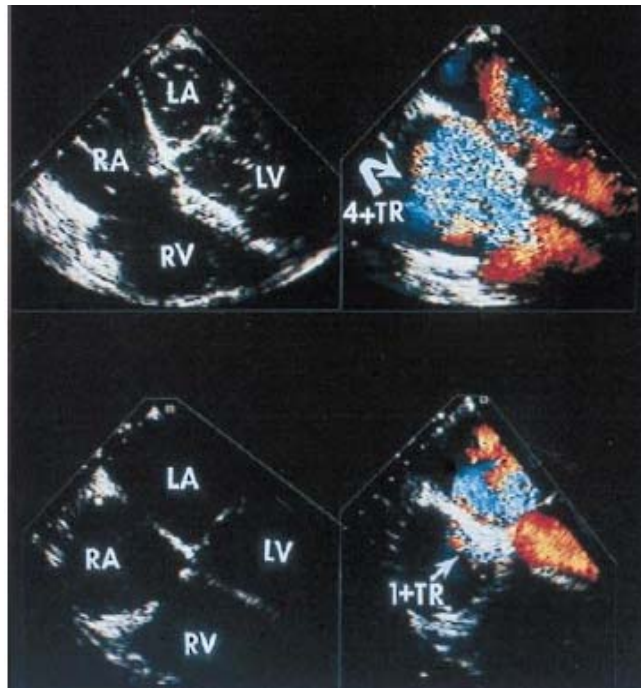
Color Doppler images of various degrees of tricuspid regurgitation. A clear increase in the jet can be seen from trace (1+) to severe (4+) (Bajzer et al. 2008).
